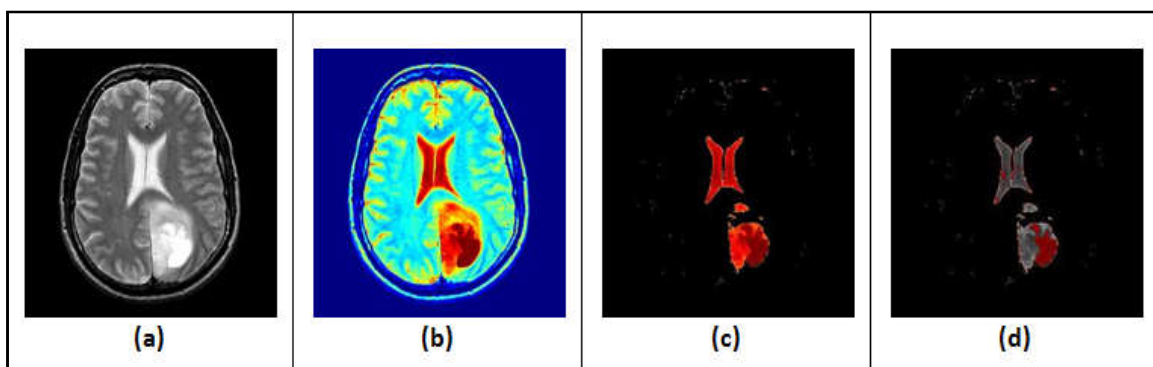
Results of proposed work (a) Original T2-weighted MRI Image (b) Colour converted image (c) Rust colour image for tumor region (d) Brown colour image for necrotic region
